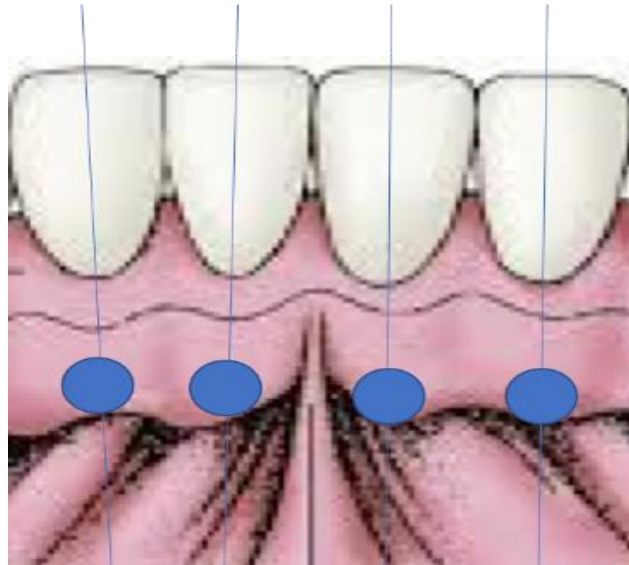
Ultrasound measurement locations (blue dots), located mid-buccal (blue lines) and tangent to MGJ within KT.
